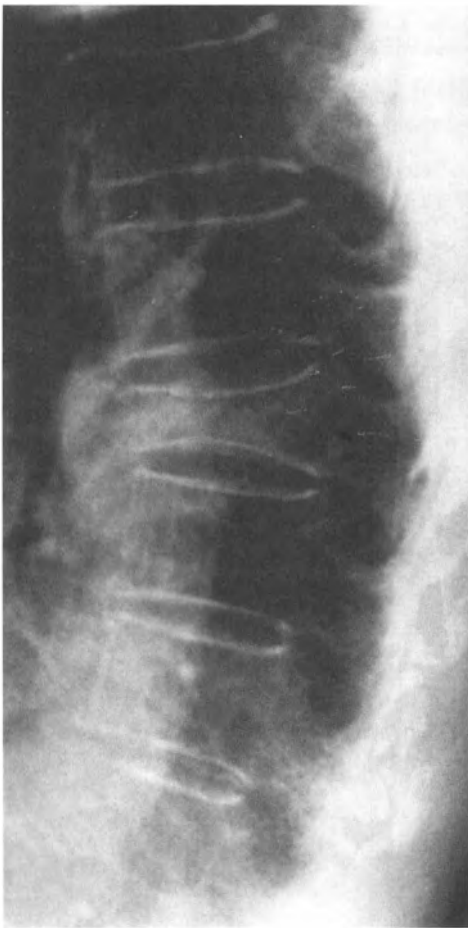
is a lateral radiograph showing an approximate 60% loss of vertical height of the T9 vertebral body, which occurred in this 59-year-old woman after a fall. Her pain continued, and Figure 4.40 represents the same radiograph taken 3 months following Figure 4.39. Note that the compression fracture has continued to
